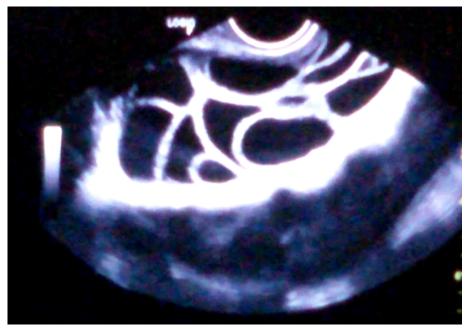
Brighten capsule of the ovary by increasing gain of the ultrasound machine.
